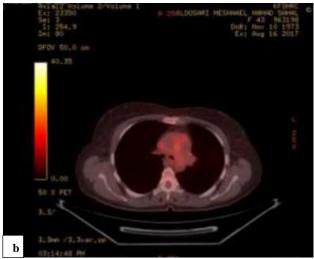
(a and b) PET-CT whole body showing significant metabolic improvement in inflammatory disease process involving and surrounding mediastinal vessels and the left lung main trunk.
